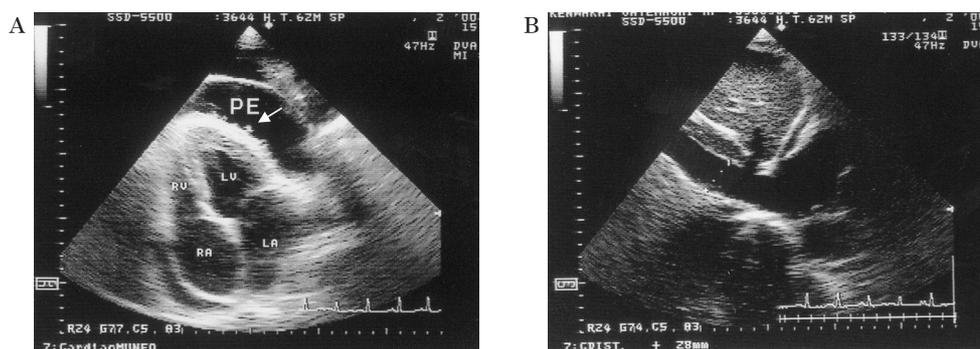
A : A preoperative transthoracic wall echocardiogram (four chamber view from the subxyhoid approach). The visceral pericardium was thickened with frond-like structures protruding in the pericardial cavity (arrow). PE=pericardial effusion, RV=right ventricle, LV=left ventricle, RA=right atrium, LA=left atrium.
